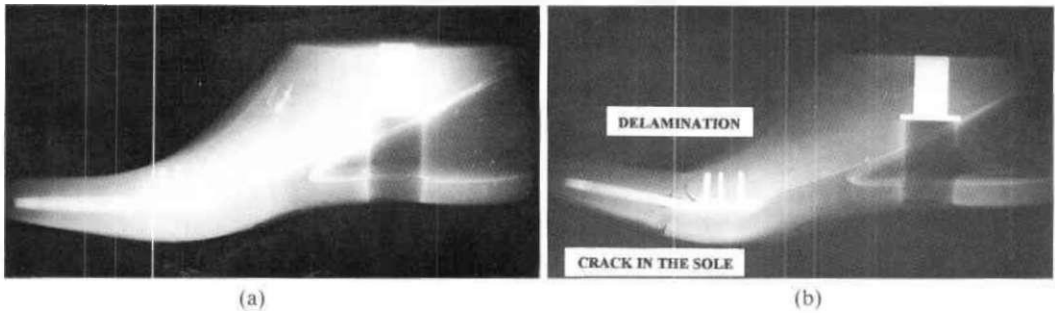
(a) X-ray lateral view of Proteor SACH foot before cycling. (b) X-ray lateral view of Proteor SACH foot after cycling.
